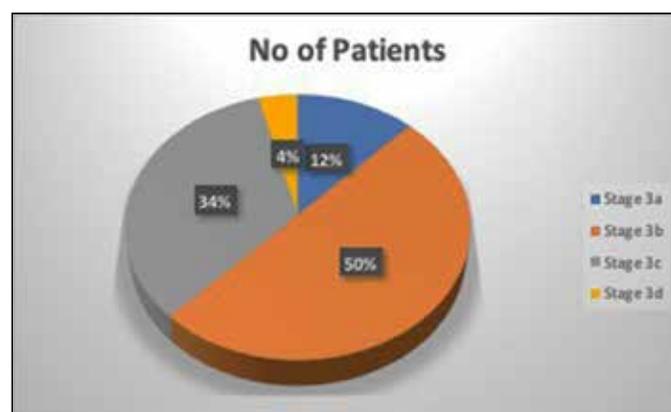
Staging of ocular manifestations on basis of contrast enhanced MRI in patients with Mucormycosis
